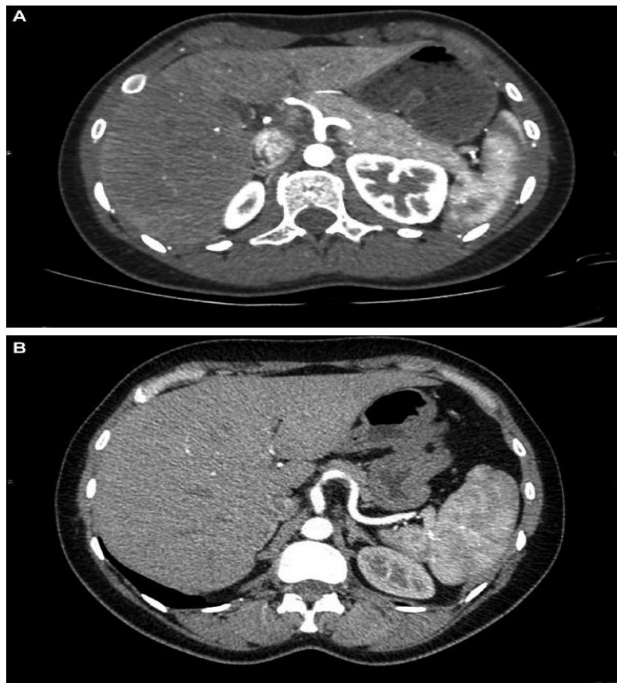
(A) Radiation dose of liver donor CT angiography (CTA) at 80 kilovoltage peak (kVp). (B) Radiation dose of a liver donor CTA at 120 kVp. Representative images from both CTAs show similar image quality in these similar-size patients but substantial reduction in total examination Dose-Length Product (DLP) using low-kVp technique and slightly shorter z axis coverage.
